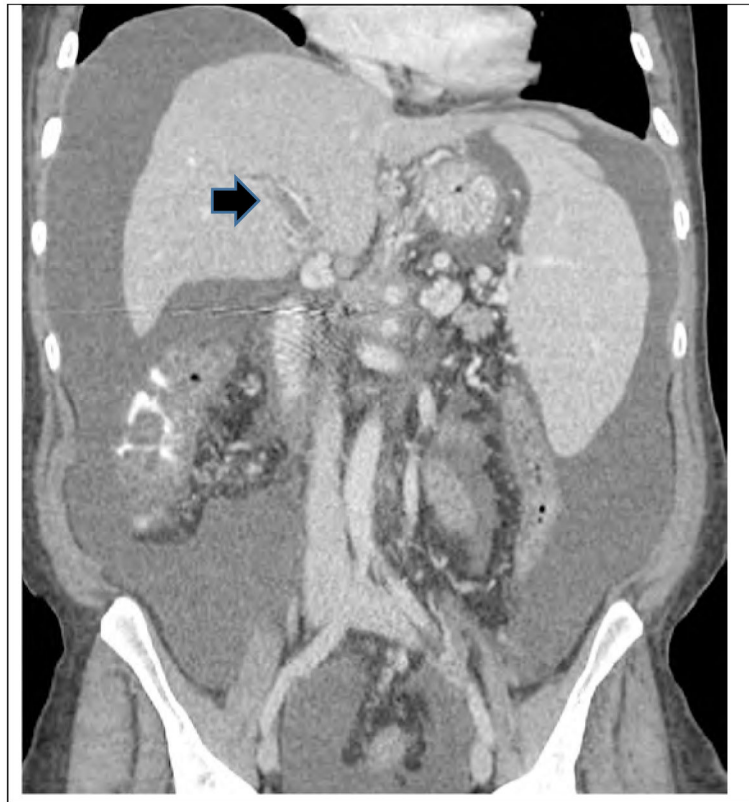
CT scan with contrast of a 55 year old female patient with PDAC who developed portal vein thrombosis (arrow).
